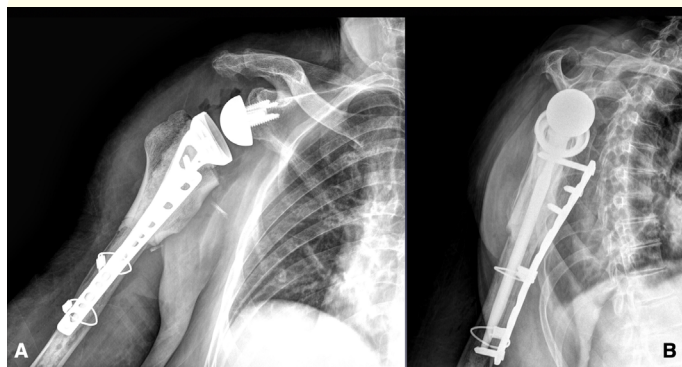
Post-operative radiograph of the revision surgery.
